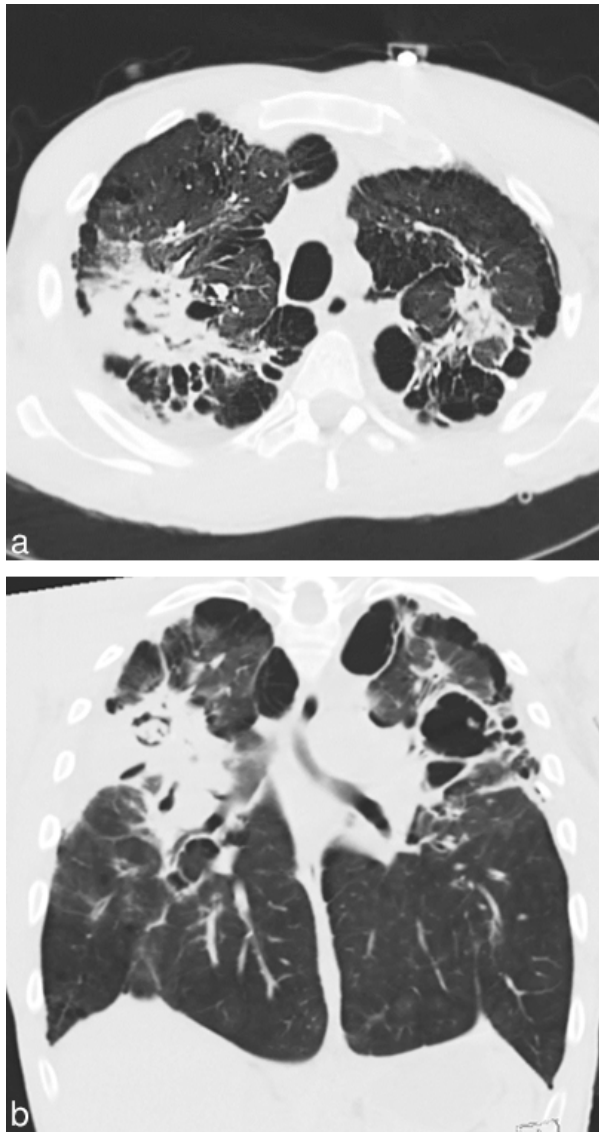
Radiographic appearance of fibrosing CPA on axial (a) CT images with coronal (b) reconstruction showing extensive parenchymal destruction with cavitation, bronchiectasis and an aspergilloma in the right-upper lobe.
